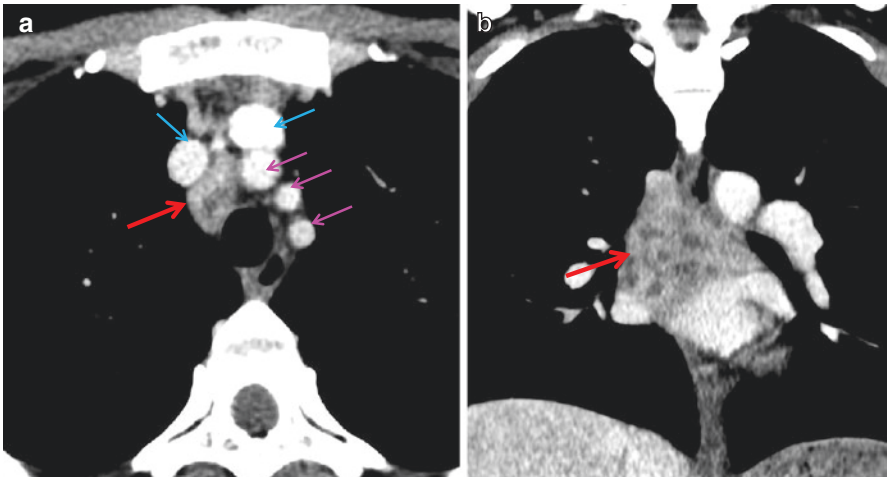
(a) Axial slice of a contrast enhanced CT thorax at the level of the superior mediastinum. There is an enlarged right para-tracheal lymph node (red arrow) with peripheral enhancement and low attenuation centre. These appearances are typical of caseous necrosis seen in TB. Note vascular structures, 3 aortic arch branches (pink arrows) and 2 brachiocephalic veins (blue arrows). (b) Coronal slice of the same patient at the level of the left atrium. A cluster of abnormal enlarged subcarinal nodes (red arrow) with typical necrotic appearances of caseous nodes
